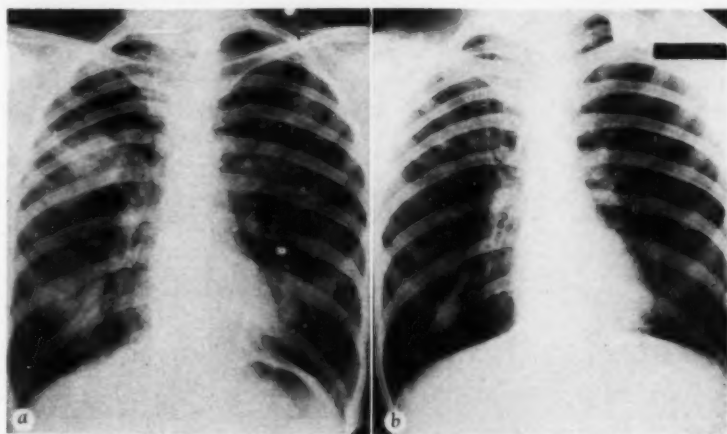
(case 1) a and b: Remarkable clearing of the lungs has occurred in the interval of 12 days represented by the roentgenograms. This followed administration of ACTH and was accompanied by complete relief of symptoms.
